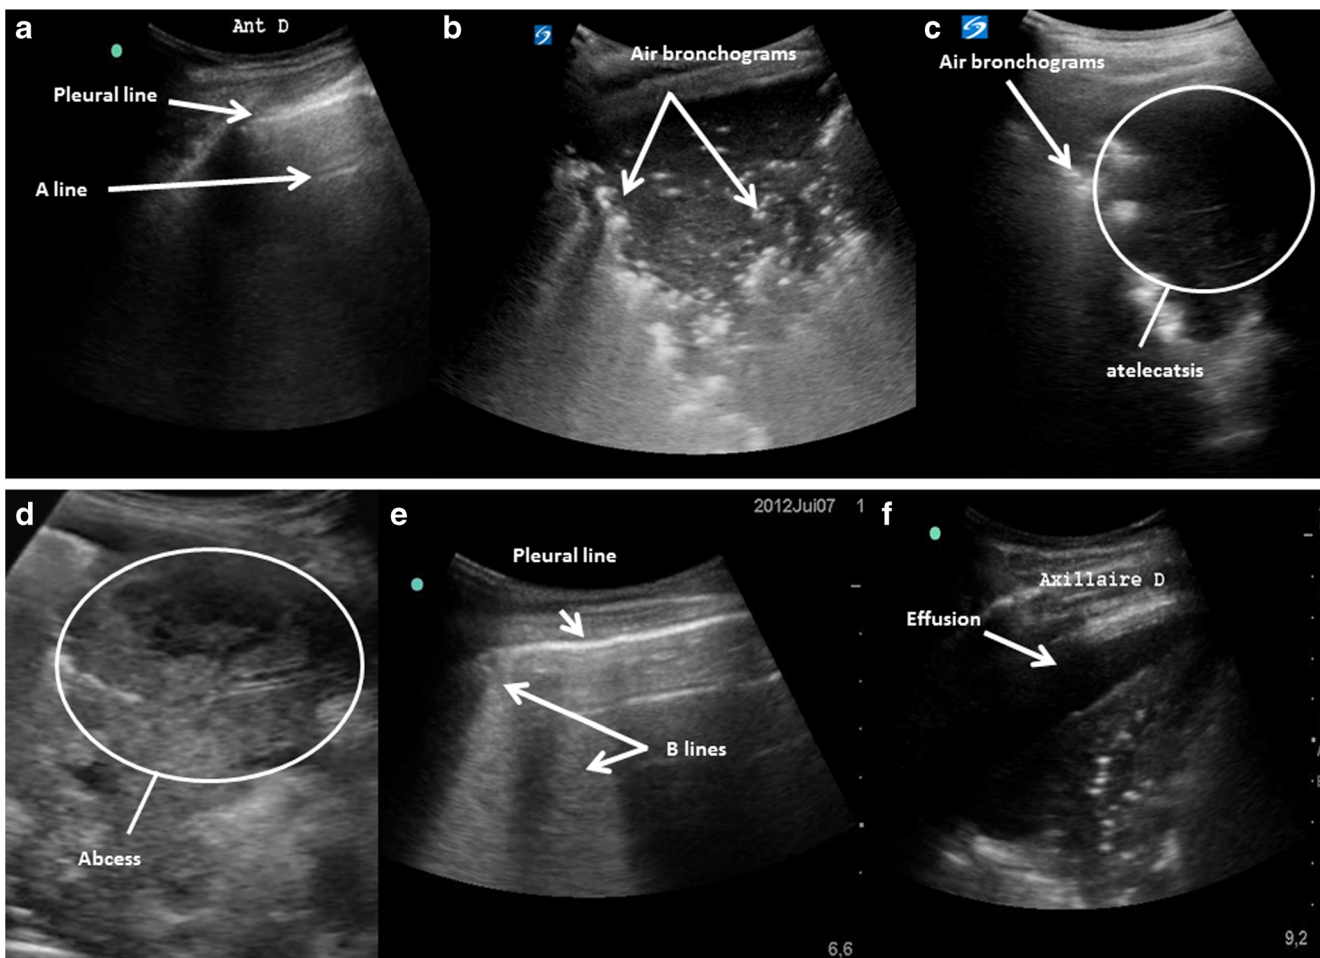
Normal and pathological lung aspects of ultrasounds images
